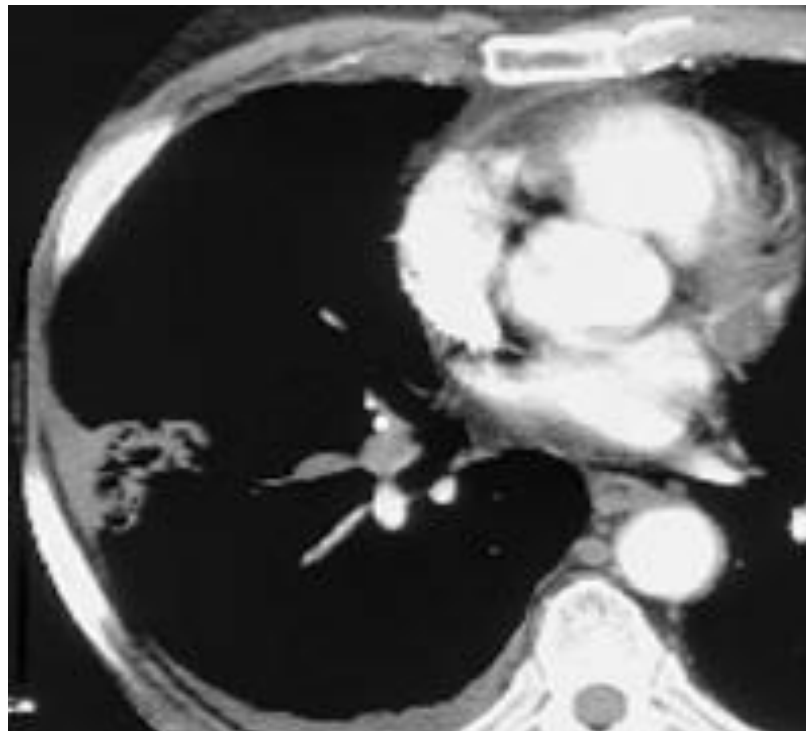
shows Computed tomography angiogram in a 53-year-old man with acute Pulmonary embolism. This image shows an intraluminal
